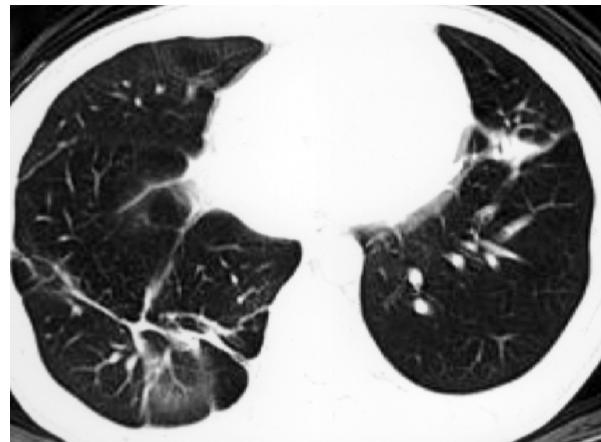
Follow-up chest CT in case 1, 4 months after discharge, demonstrating mild fibrotic changes.
